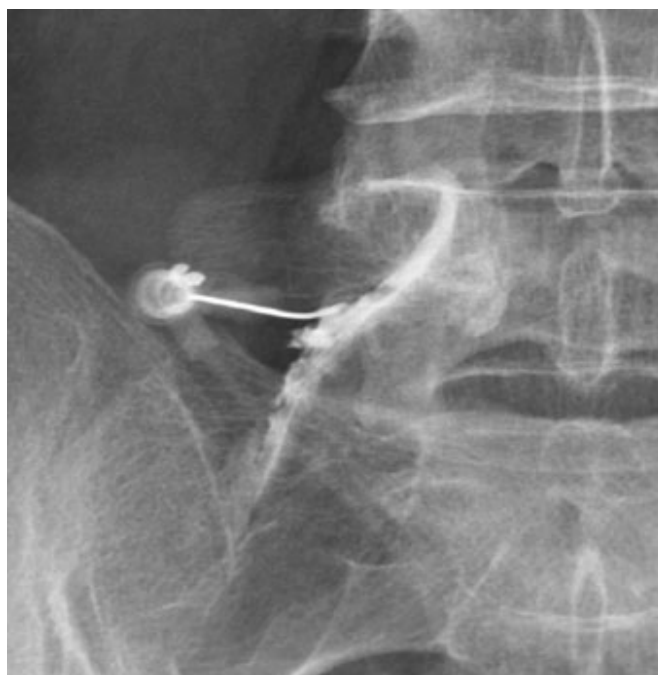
In this patient, left L5 radiculopathy correlated with left-sided L4-5 disk herniation on MRI. The fluoroscopy image shows the needle placed next to the left L5 nerve with contrast material outlining the nerve and flowing into the spinal canal to the level of the L4-5 disk. Pain decreased from 8/10 to 1/10 over 5 days.
